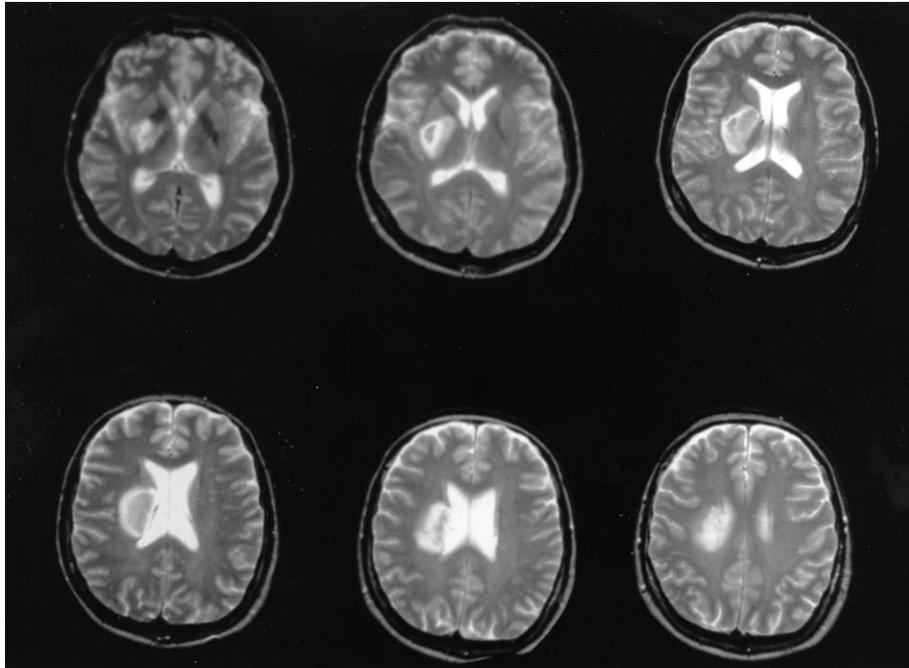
A CT scan for Patient 2 revealing right-sided infarction of the putamen, globus pallidus and posterior limb of the internal capsule.
